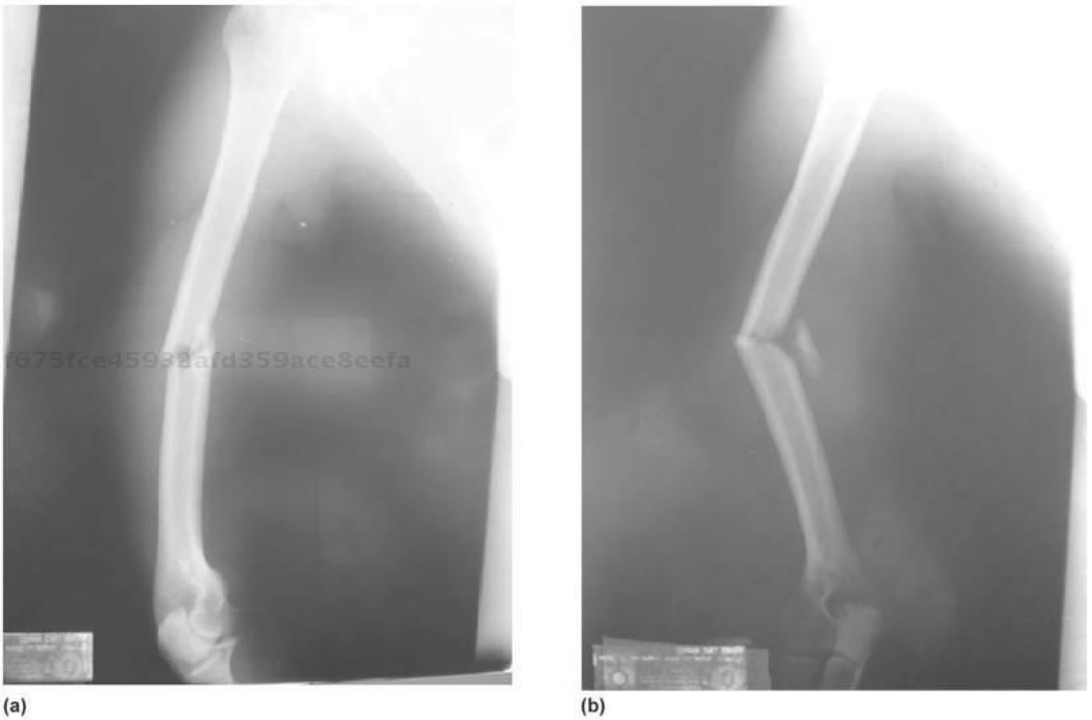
X-rays showing the fracture and surgical treatment. (a) and (b) Anteroposterior and lateral x-rays of the fracture. (c) and (d) Surgical treatment, a wide straight plate with nine orifices of 4.5 mm. Courtesy of Carlos de la Garza-Páez, M.D.
